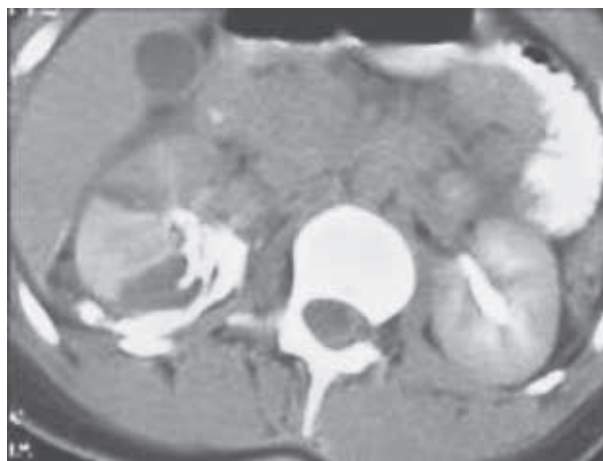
Damage to the kidney (CT)
